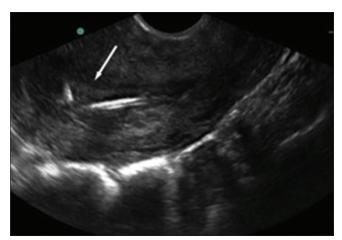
Transvaginal sonography showing displaced intrauterine contraceptive device
